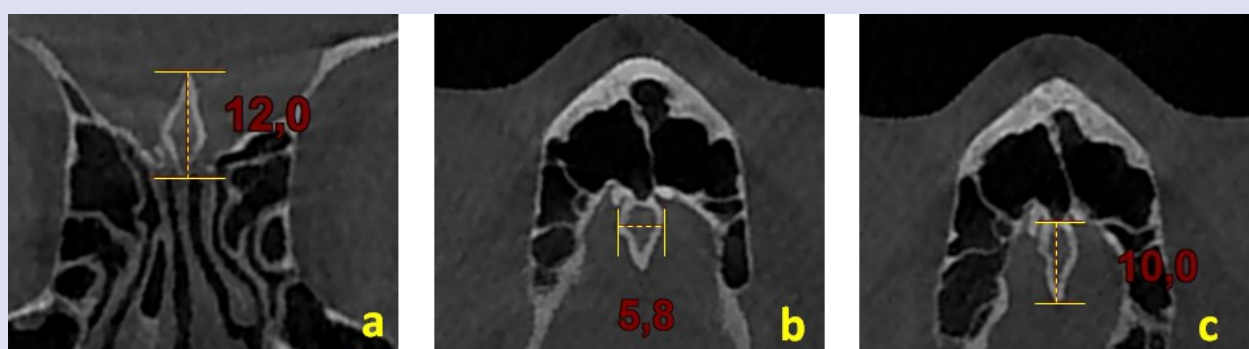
CG measurements. a) Measurement of the height of the CG on coronal CBCT slice. b) Measurement of the width of the CG on axial CBCT slice. c) Measurement of the length of the CG on axial CBCT slice.
